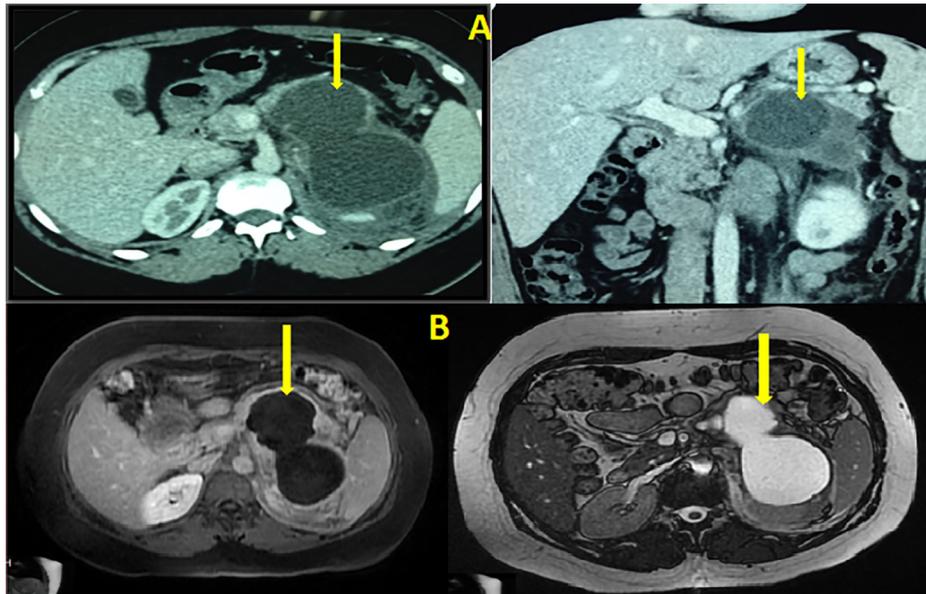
A. CT scan. B. MRI.
